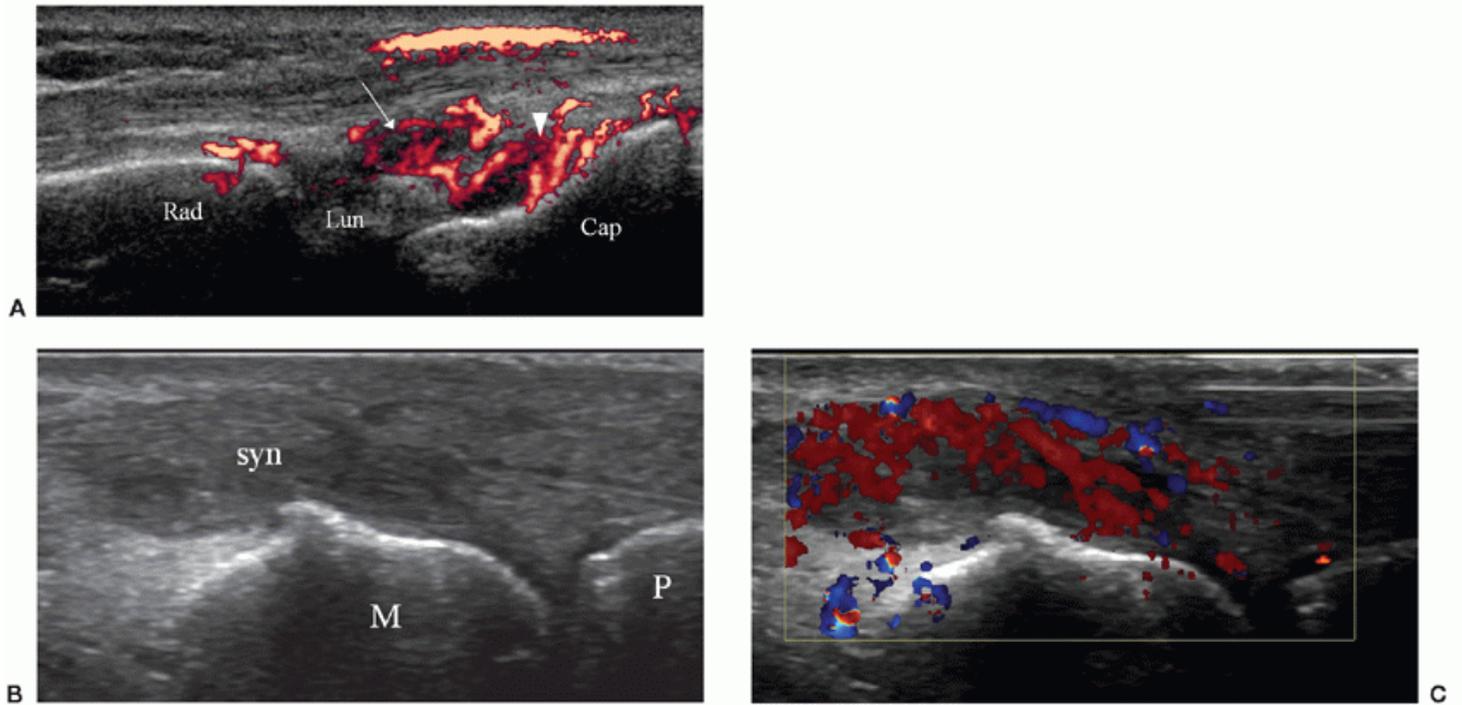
Rheumatoid arthritis patients. A: Dorsal longitudinal ultrasound scan of the wrist shows synovial thickening in the recesses of the radiocarpal (arrow) and midcarpal (arrowhead) joints. Synovial hyperemia on power Doppler examination confirms active synovitis. Rad, radius; Lun, lunate; Cap, capitate B: Dorsal longitudinal ultrasound scan of the third MCP joint shows synovial thickening (syn) extending from the joint line and along the metacarpal head (M). P, proximal phalanx. C: Synovial hyperemia on color Doppler examination confirms active synovitis.
